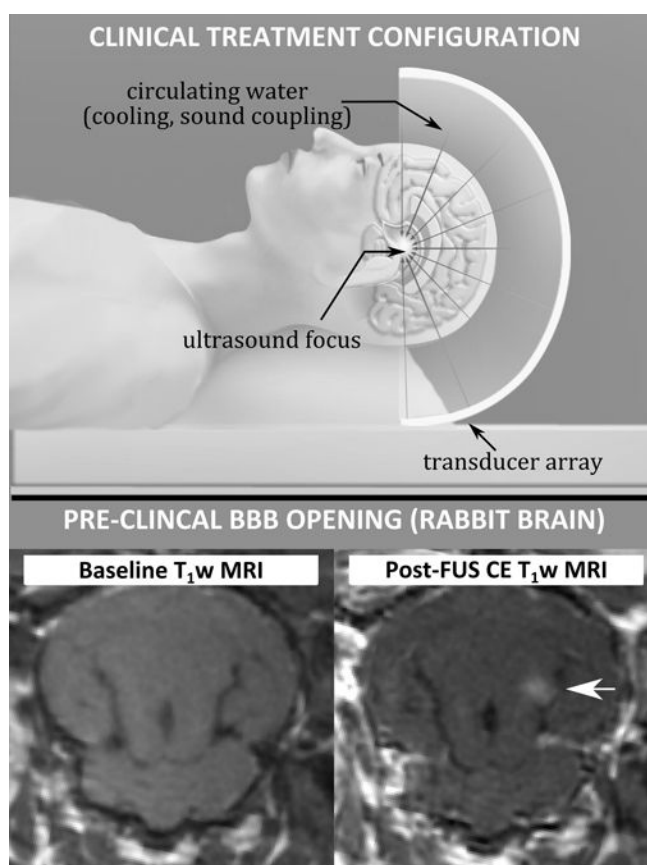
(Top) Treatment setup for ultrasound therapy using a large aperture array. (Bottom) Baseline axial T₁-weighted MRI of a rabbit brain, and corresponding post-FUS, contrast-enhanced image showing enhancement indicating disruption of the BBB at the treated location (arrow).
